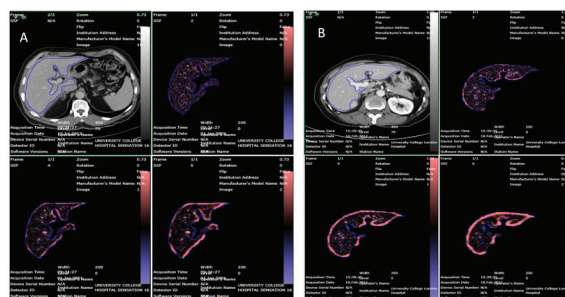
CT Texture Analysis in rectal cancer patients that A. Developed hepatic metastasis; and B. Did not develop hepatic metastasis after a 5 year or greater follow-up interval
